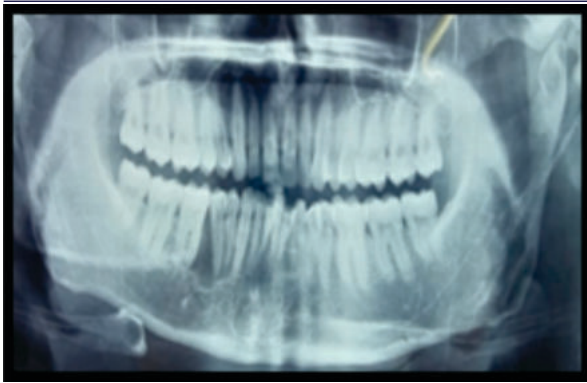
Panoramic radiographs showing a single large expansile mixed radiopaque-radiolucent lesion.
